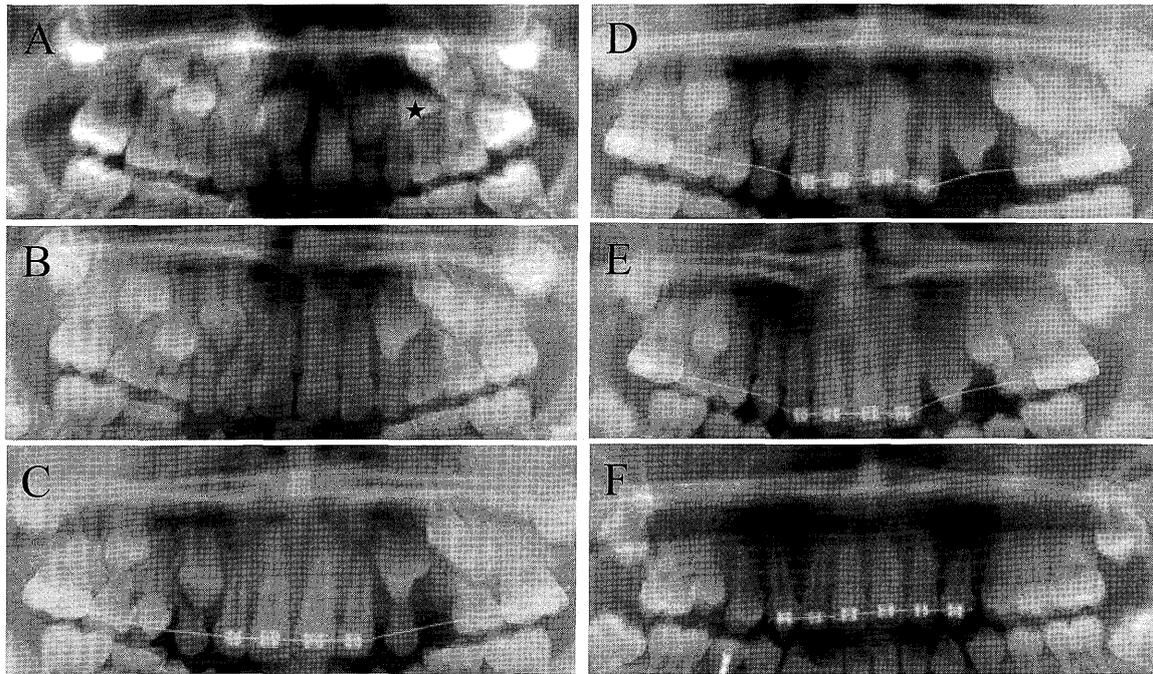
The orthopantomograms of treatment course in Case 9
